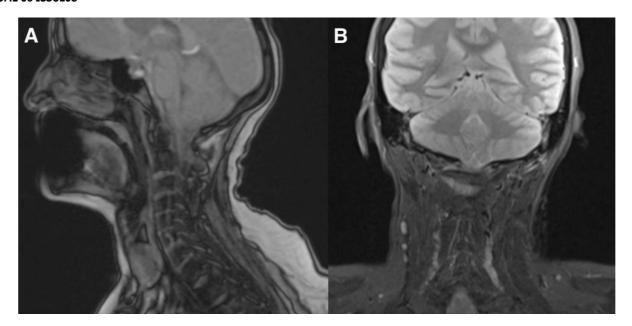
Neck MRI in Case 2.
